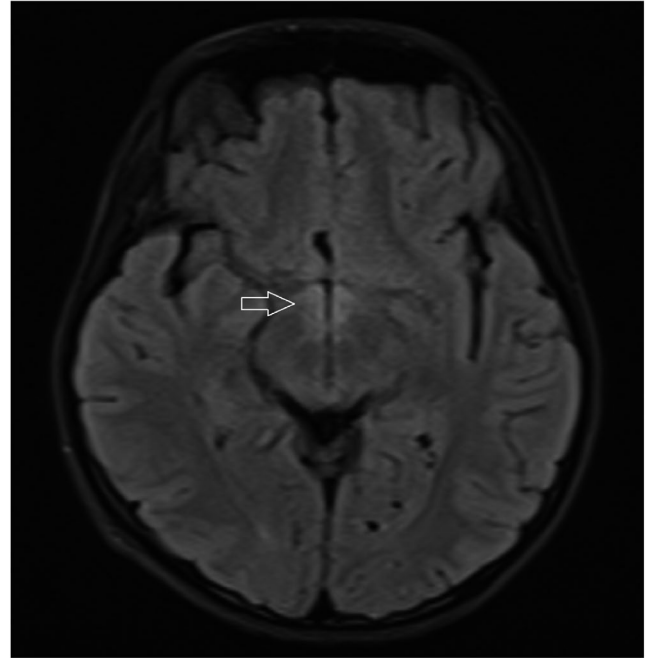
FLAIR MRI image of the patient showing hyperintensity in bilateral hypothalamus (white arrow)
